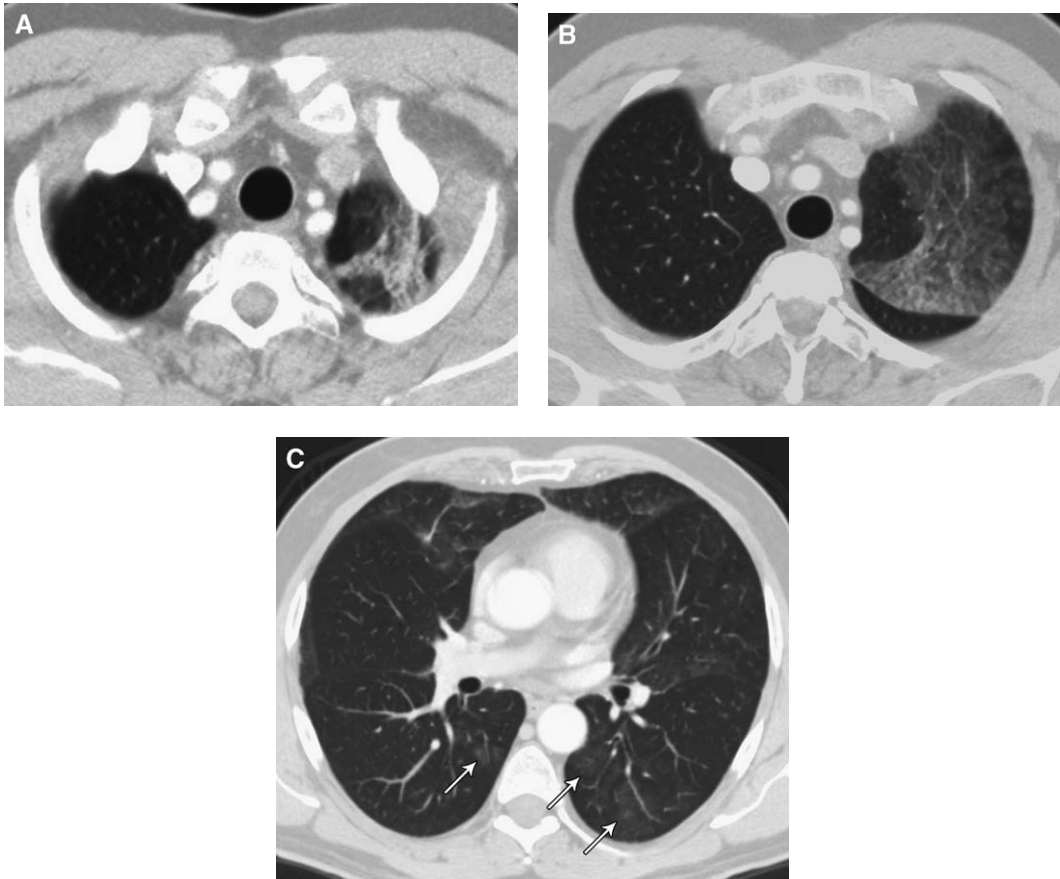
A 57-year-old man with history of bronchioloalveolar cell carcinoma of the left upper lobe. (A) CT scan of upper lobes shows primary tumor. (B) CT scan shows diffuse ground glass opacification that was metastatic disease on biopsy. (C) Lower lobes show metastases manifesting as ground glass nodules (arrows).
